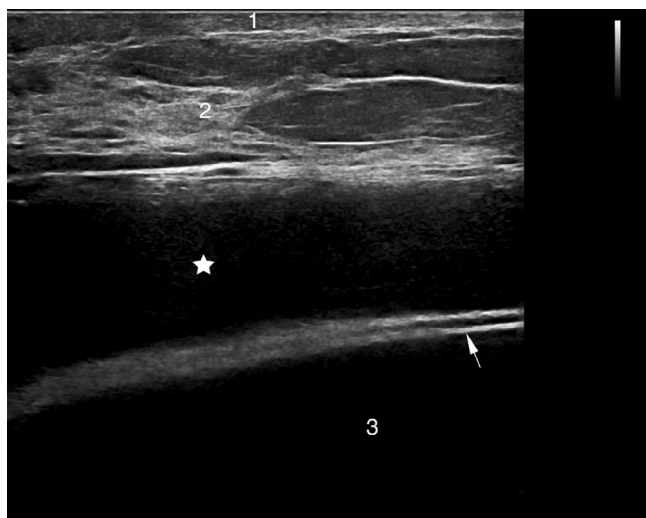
Initial ultrasound findings, in a transverse scanning plane: The initial ultrasound revealed a diffuse fluid collection surrounding the right breast implant. Skin (1), Breast tissue (2), Breast implant (3), Implant shell (arrow), Fluid collection (asterisk)
